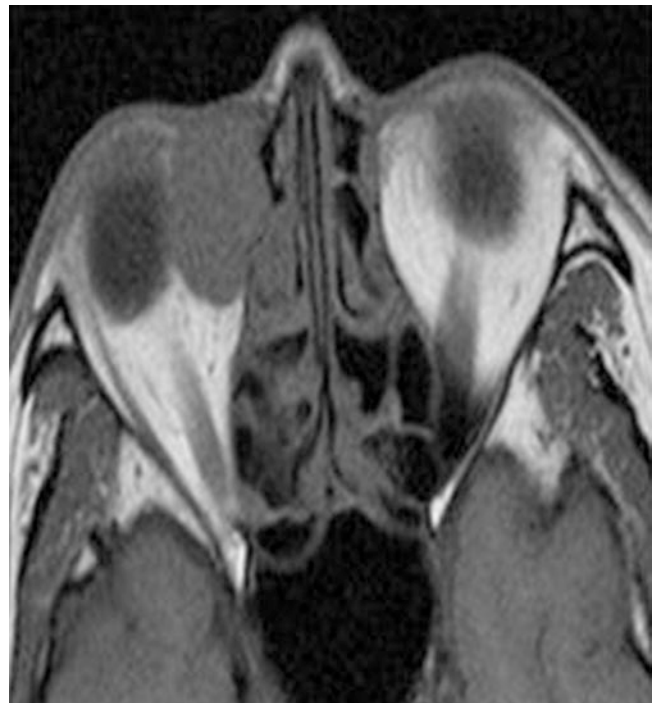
MRI, T1-weighted, axial cut showing a lacrimal sac mass lesion abutting and displacing the globe. Note the lesion is hypointense on T1
